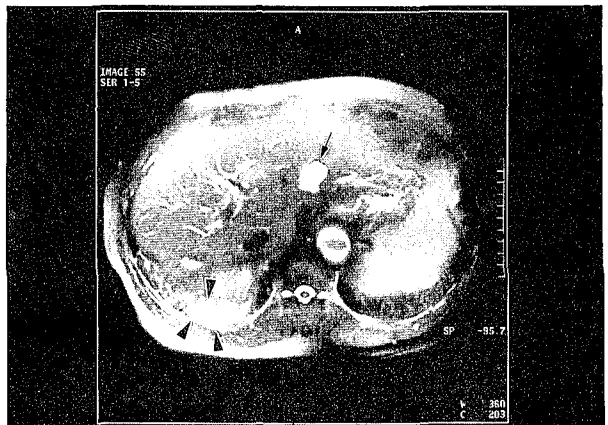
Magnetic resonance imaging revealed a large cyst (arrow) in the lateral segment of the left hepatic lobe, and the presence of biloma in the lower lobe of the right lung (arrowhead).
